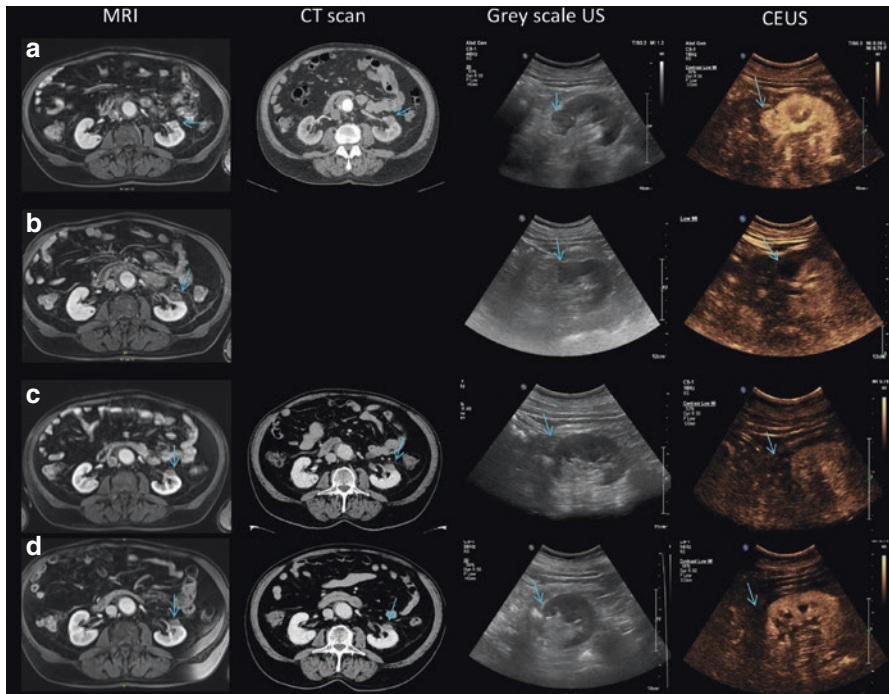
Initial and follow-up imaging after irreversible electroporation of a kidney tumor. (a) Small renal mass in the anterior kidney. MRI T2-weighted imaging and CT scan show enhancement of the mass clearly depicted in the gray-scale ultrasound and with vascularity present on contrast-enhanced ultrasound (CEUS). (b) One week after irreversible electroporation, there is no enhancement in T2 contrast-weighted MRI, and there is a slight increase in the size of the ablated lesion and absence of vascularity on CEUS. (c) Three months after IRE, MRI and CT show contraction of the ablated lesion without enhancement. Additionally, there is absence of contrast diffusion on CEUS. (d) At 6 months there is absence of contrast enhancement on MRI and CT, hyperechogenicity on gray-scale ultrasound which is a possible indirect sign of fibrosis, and an absence of vascularity on CEUS
